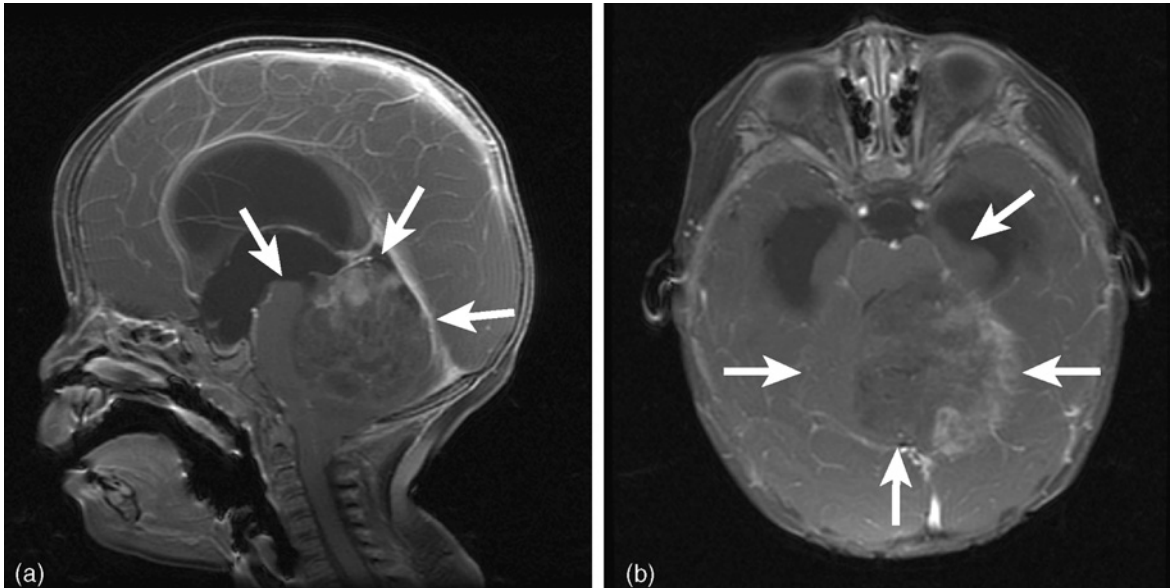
Medulloblastoma. An MRI scan showing a massive posterior fossa tumour blocking the fourth ventricle in (a) sagittal section and (b) transverse section. The tumour is indicated with an arrow.
